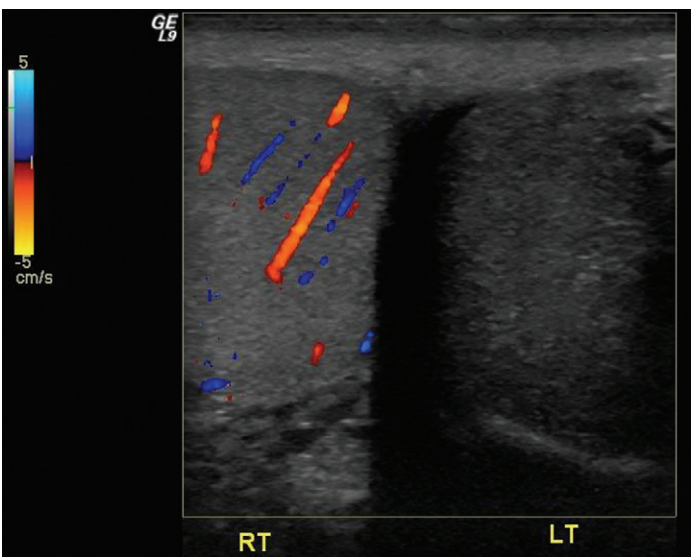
Testicular torsion. Doppler ultrasound confirms blood flow to the right testis. No blood flow to the left testis is evident; in this case, absence of blood flow was due to torsion of testis and spermatic cord. (Image courtesy of Vikram Dogra, MD.)
